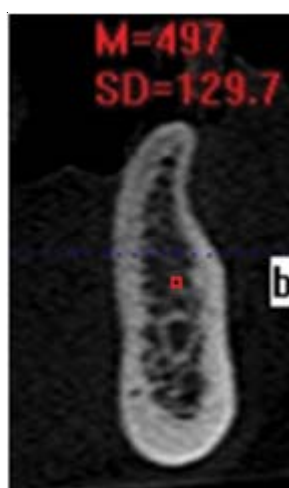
CBCT cross-sectional views perpendicular to the axial plane
